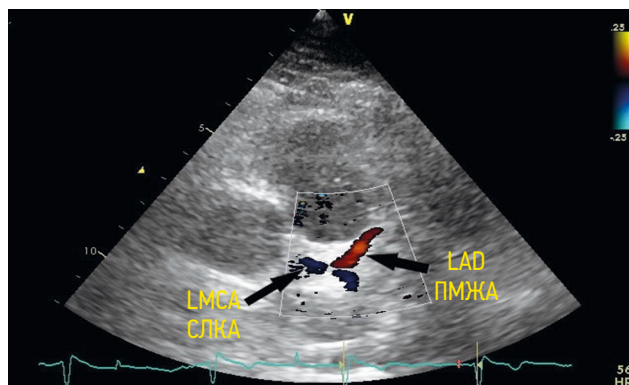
Visualization of the left main coronary artery from a modified left parasternal position along the long axis. LMCA — left main coronary artery; LAD — left anterior descending artery
